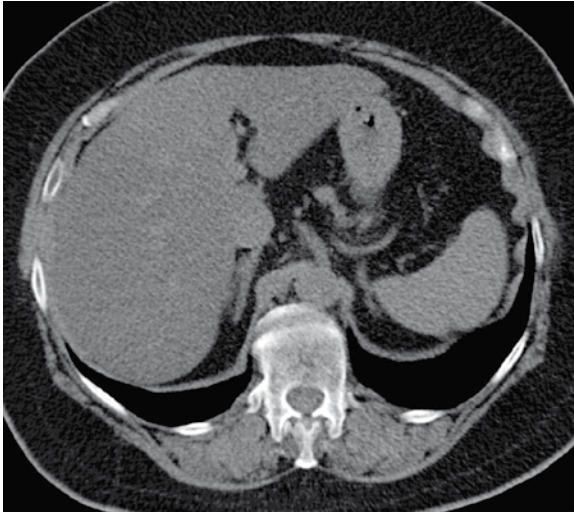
Non-alcoholic fatty liver disease on computed tomography (CT): Liver is darker than spleen on non-contrast axial image consistent with fatty infiltration.
